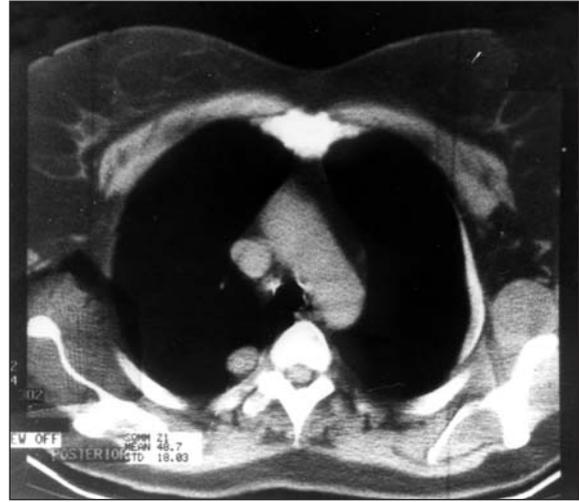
CT of the thorax demonstrated a well-circumscribed solitary pulmonary nodule in posterior segment of right upper lobe, which was localized paravertebrally.
